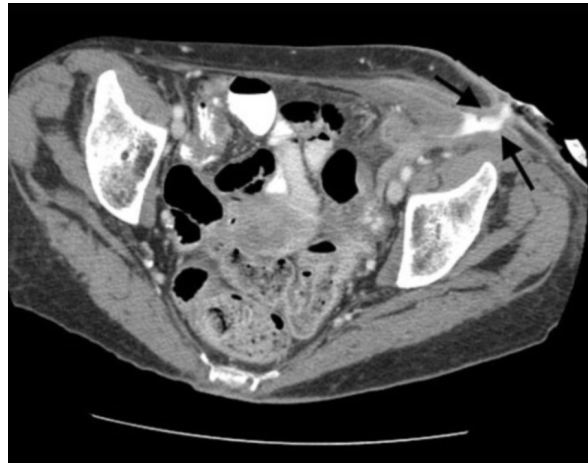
Axial CT shows contrast (arrows) within the enterocutaneous fistula and spilling out onto skin.
